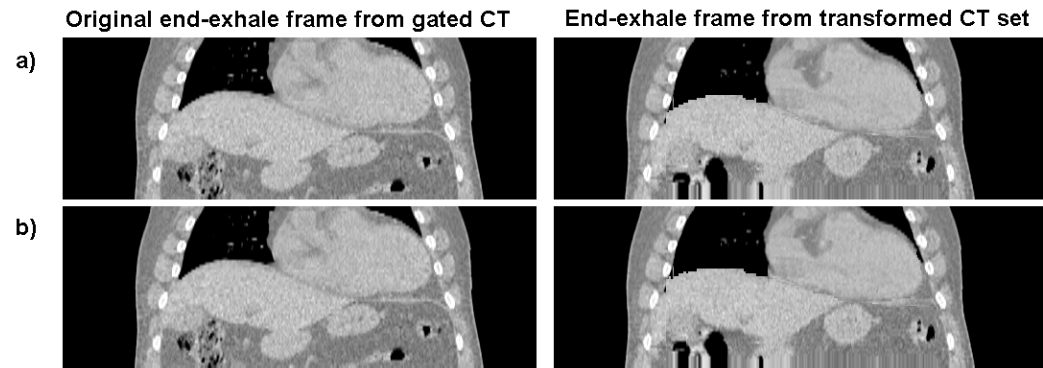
Coronal views of the end-exhale frames from the original and transformed CT datasets for patient 2, where the abdomen transformation has been obtained using a) the all-patient model shape and b) the leave-one-out shape model. Please see Appendix B.4.3 for the animations of these sets.
